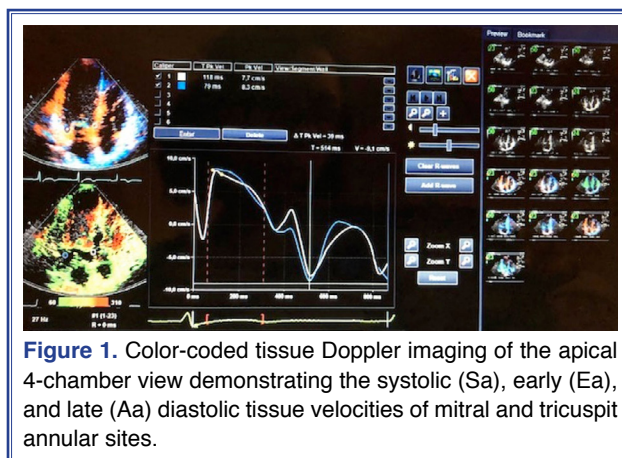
Color-coded tissue Doppler imaging of the apical 4-chamber view demonstrating the systolic (Sa), early (Ea), and late (Aa) diastolic tissue velocities of mitral and tricuspid annular sites.
